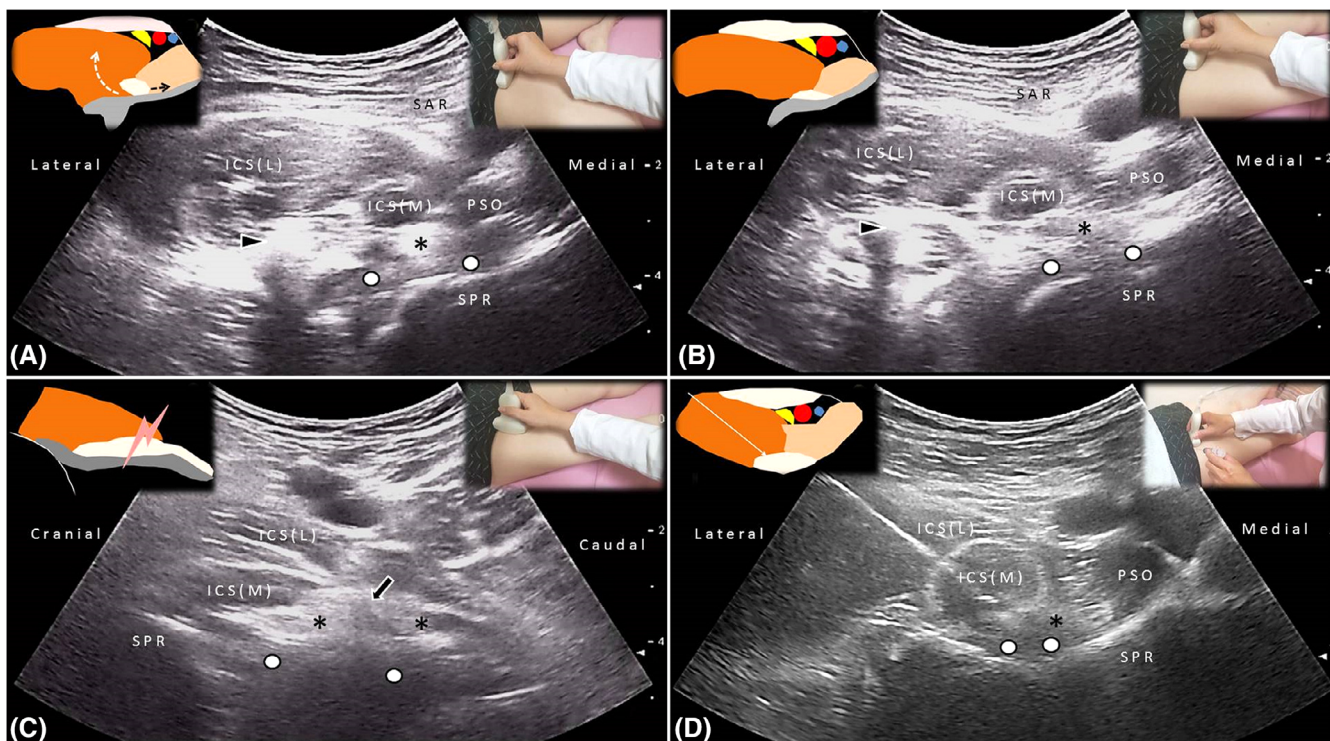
The iliopsoas tendon (*) is encircled by the iliacus muscle when the hip is flexed and externally rotated (A). The iliopsoas tendon abruptly glided medially when the hip is extended to the neutral position (B). A flash (arrow) of the iliopsoas tendon is visualized during repeated hip flexion and extension (C). Ultrasound guided hydrodilatation with a mixture of 5 mL 50% dextrose and 5 mL 1% lidocaine is introduced between the iliacus muscle and iliopsoas tendon (D). Arrowhead: anterior inferior iliac spine; White circles: iliofemoral ligament. Abbreviations: ICS (L), iliacus muscle (lateral compartment); ICS (M), iliacus muscle (medial compartment); PSO, psoas muscle; SAR, sartorius muscle; SPR, superior pubic ramus
